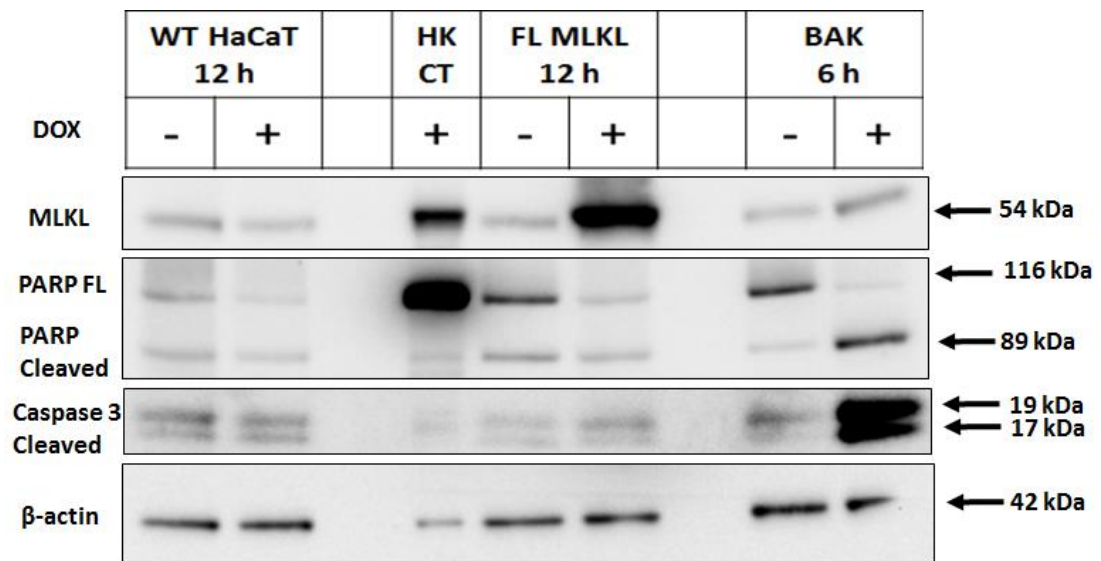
Screening for cell death markers in MLKL stable HaCaT cells via Western blotting. PARP and caspase 3 cleavages were assessed for MLKL stable HaCaT in comparison with Bak stable and parental HaCaT. HK indicates HEK293T while CT indicates control. Positive control lysate (HK CT) was derived from transiently expressed tetracycline-inducible MLKL in HEK293T cells induced with DOX (5 µg/ml). MLKL induction in MLKL transgenic stable HaCaT cells was achieved using DOX (1 µg/ml).
